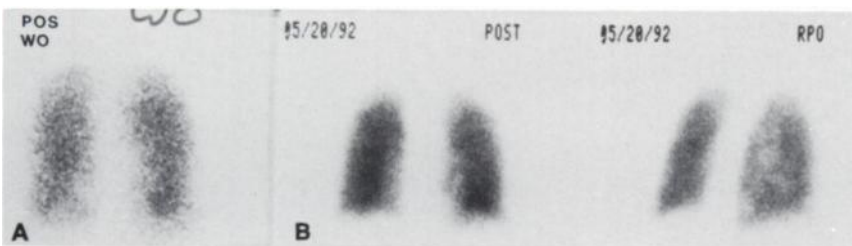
Patient 1. Paired ventilation and perfusion images obtained pre- and 5 hr post-BAL. Abnormalities appearing after BAL involve multiple segments of the RLL. The chest x-ray showed matching infiltrates. Posterior washout ventilation images (A and C); posterior and right posterior oblique perfusion images (B and D).
